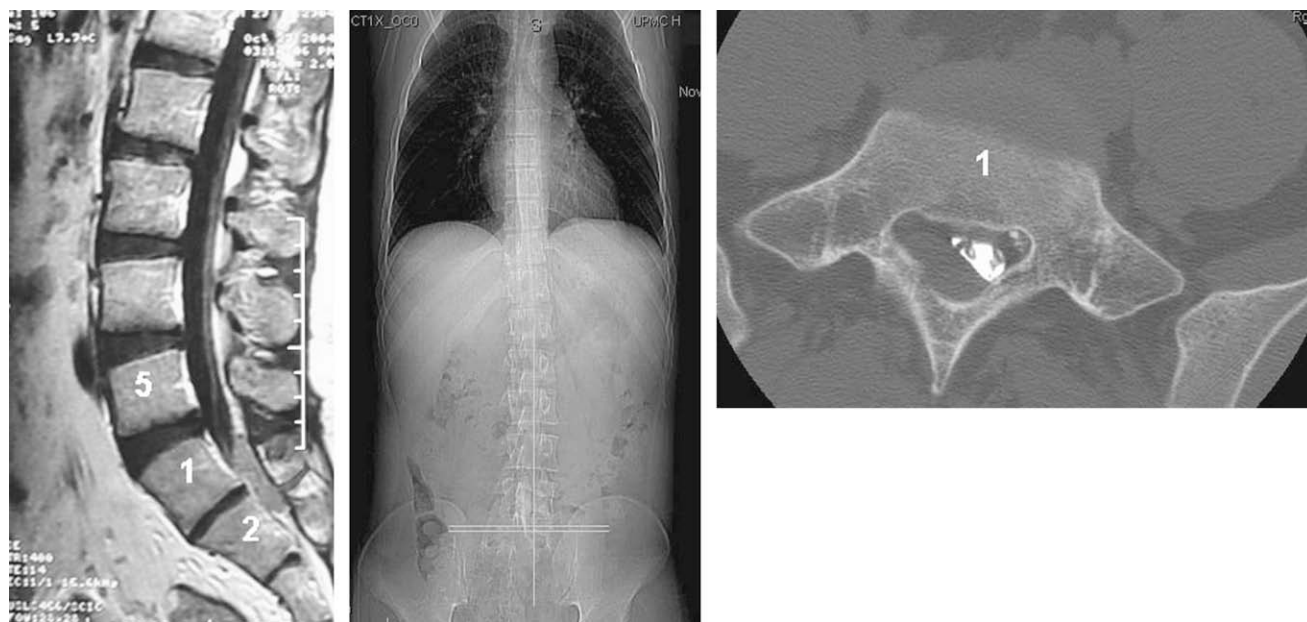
(Left) T2 sagittal MRI of the lumbosacral spine. Low-signal intensity intraspinal extradural lesion posterior to S1/2 disc. (Middle) Scout and (Right) axial CT myelogram. Intraspinous extradural lesion at S1 (low-signal intensity) and spinal cord (high-signal intensity).
